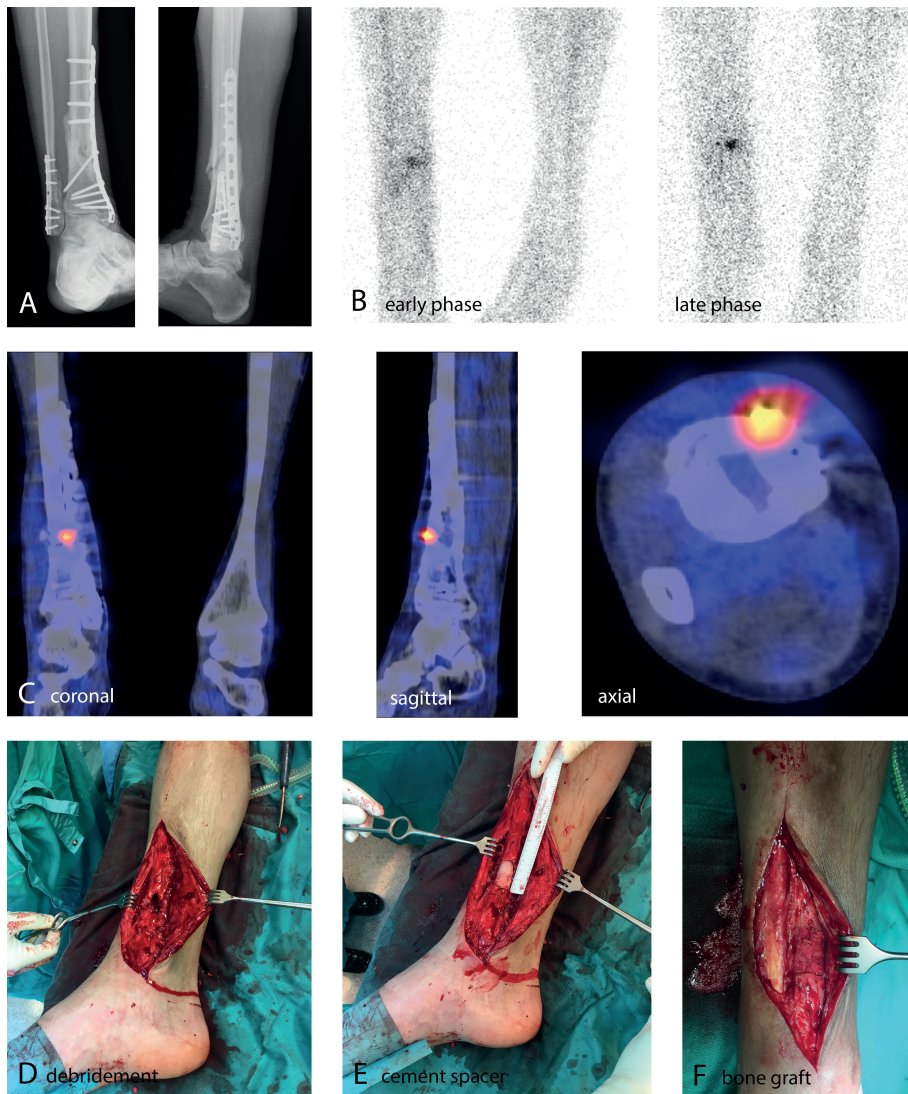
Clinical example. A 57-year-old man was treated with a plate osteosynthesis for a crural fracture (A) 10 months ago. He presented with a small area of redness and tenderness at the distal-medial tibia. WBC scintigraphy showed an increased uptake in the distal tibia in both the early and late phases (B) of the scan, with intensity increasing in time. A SPECT/CT (C) demonstrated a hotspot around the lag screw in the tibia. The patient was operated and there was an infection detected around the lag screw. All osteosynthetic materials were removed. Subsequently, the infected bone around the lag screw was debrided (D) and a cement spacer (E) was temporarily placed in a small tibial bone defect. Cultures of the implants demonstrated an *ochrobactrum intermedium* microorganism. After IV and oral treatment with antibiotics, the bone defect was filled with a cancellous bone graft during the second stage of this Masquelet procedure (F). The patient recovered uneventfully.
